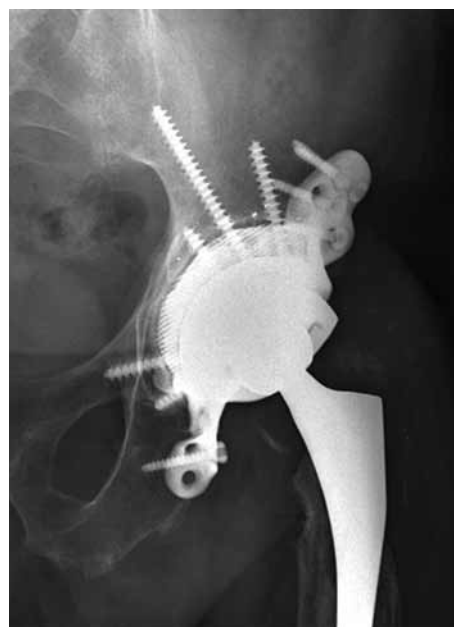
Two-year postoperative AP pelvic radiograph showing the well-fitted acetabular component and the restored centre of rotation of the hip.
